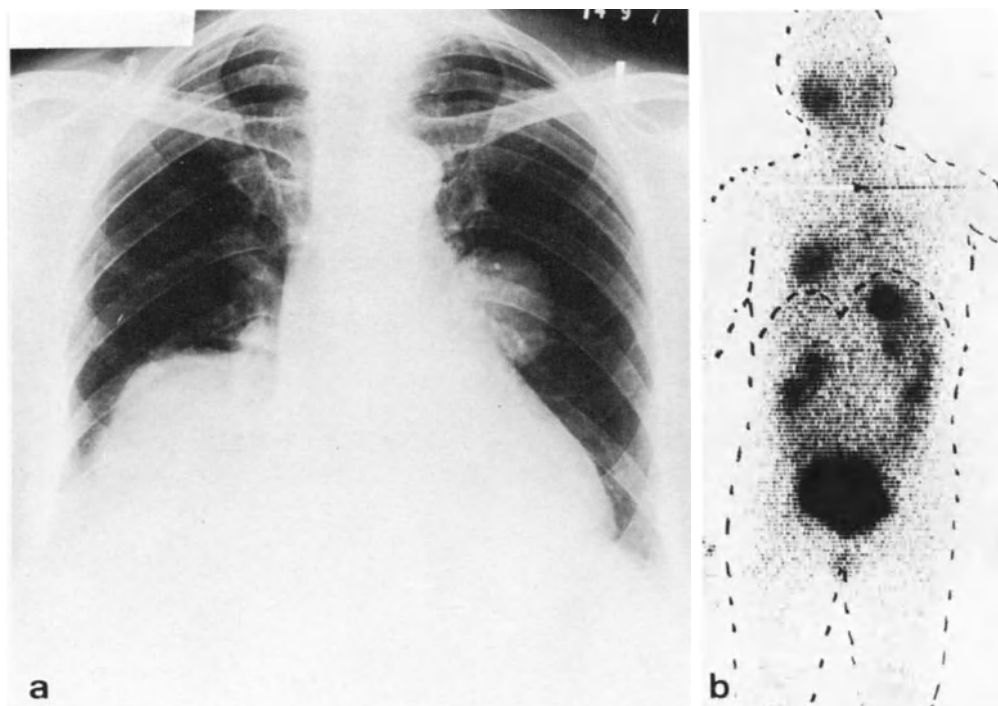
a, b. Low radioiodine uptake by poorly differentiated thyroid metastases. a chest X-ray; b ¹³¹I scan
